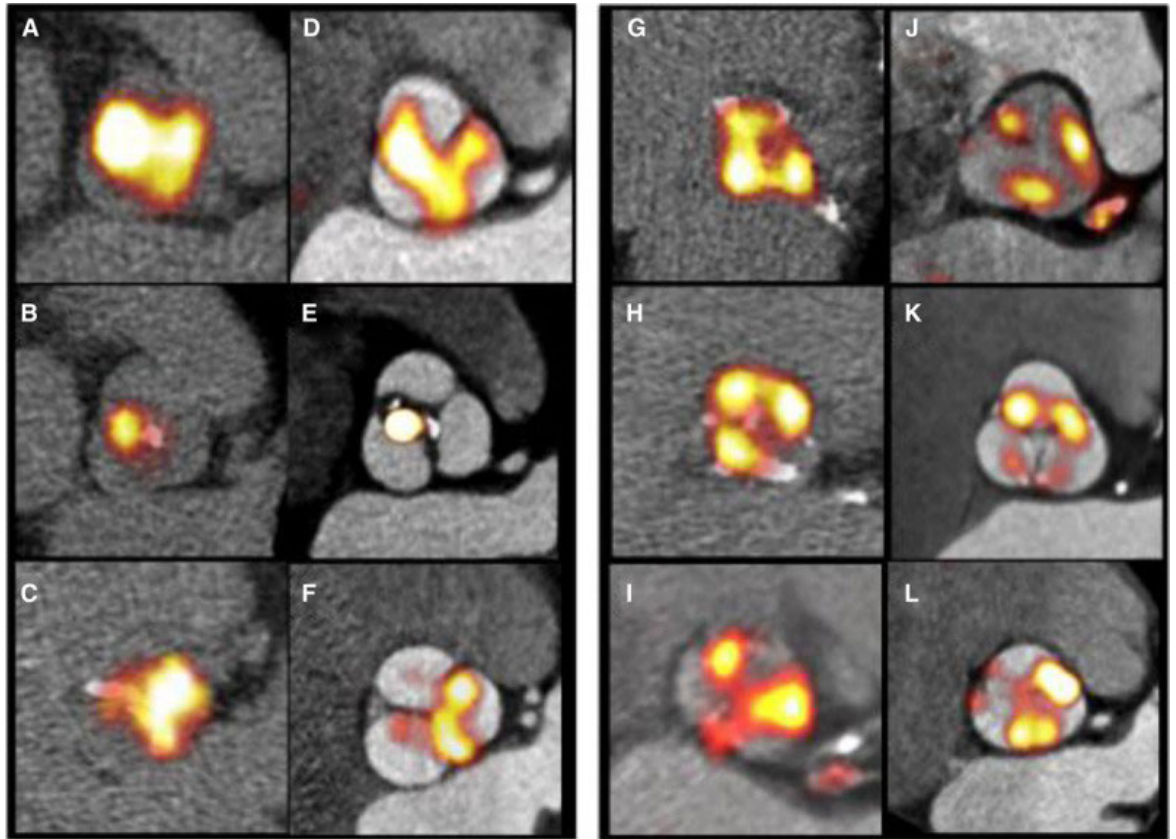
Paired non-gated, non-contrast PET/CT scans (original approach: A-C, G-I) and gated, contrast-enhanced PET/CT images (final approach: D-F, J-L). Images demonstrate the typical distribution of the tracer uptake within the valve at sites of increased mechanical stress i.e. at the leaflet tips (D-F) and at the commissures (J-L).
